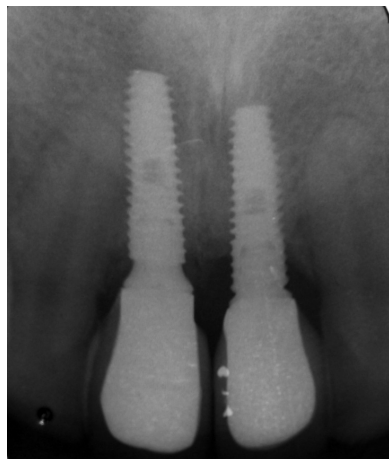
Periapical radiograph control after definitive crown placement
